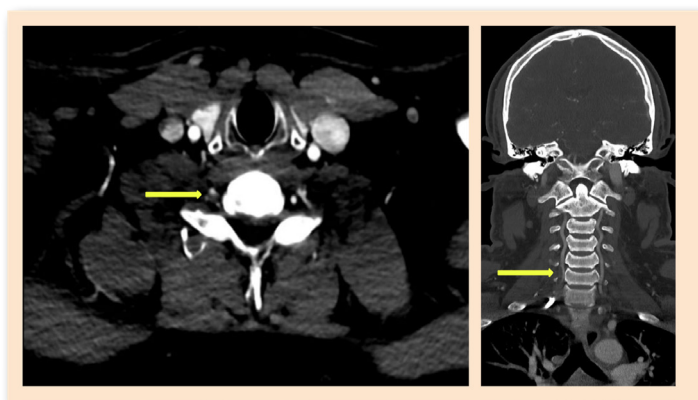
CTA: eccentric filling defect in the lateral aspect of the right vertebral artery at the level of C6 extending along a 1.6 cm segment with subintimal thrombus, resulting in moderate segmental stenosis.
